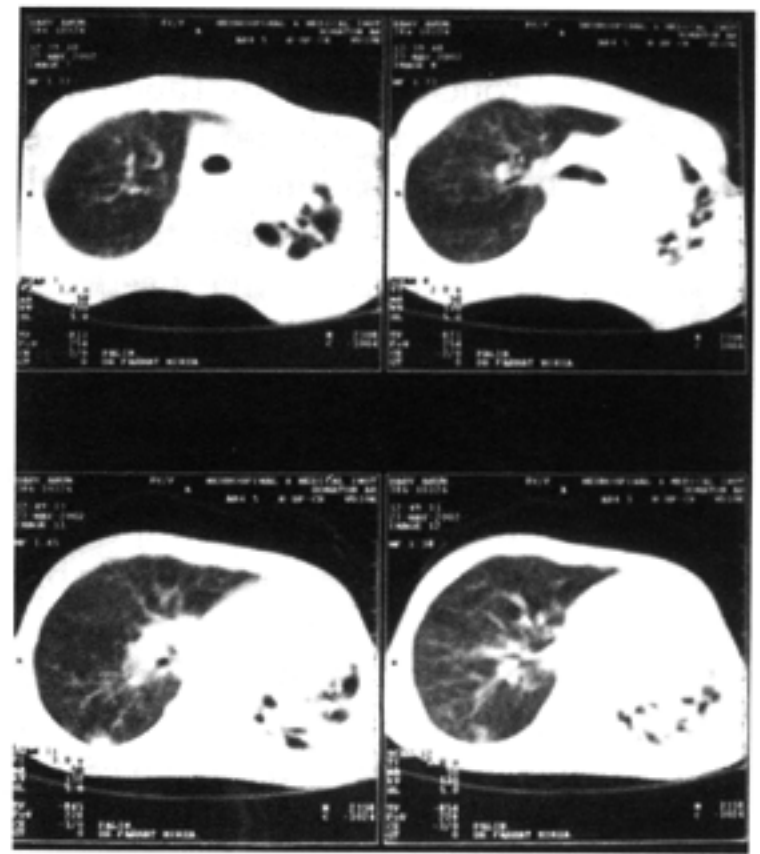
CT scan showing extensive bronchiectasis of left lung
